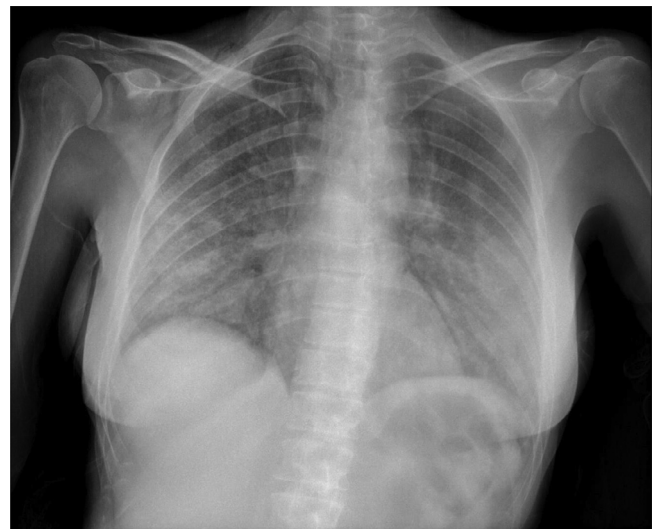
(Patient 1): Chest x-ray showing bilateral infiltrates, left-sided pneumomediastinum and subcutaneous emphysema in the neck.
